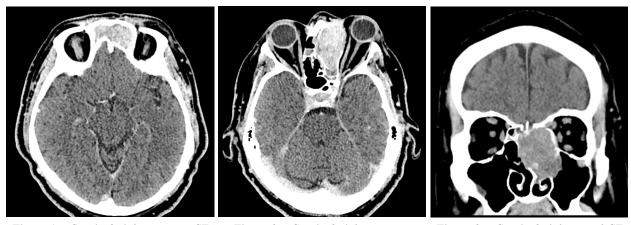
Cranio-facial transverse CT image with tumor involving left frontal sinus.
